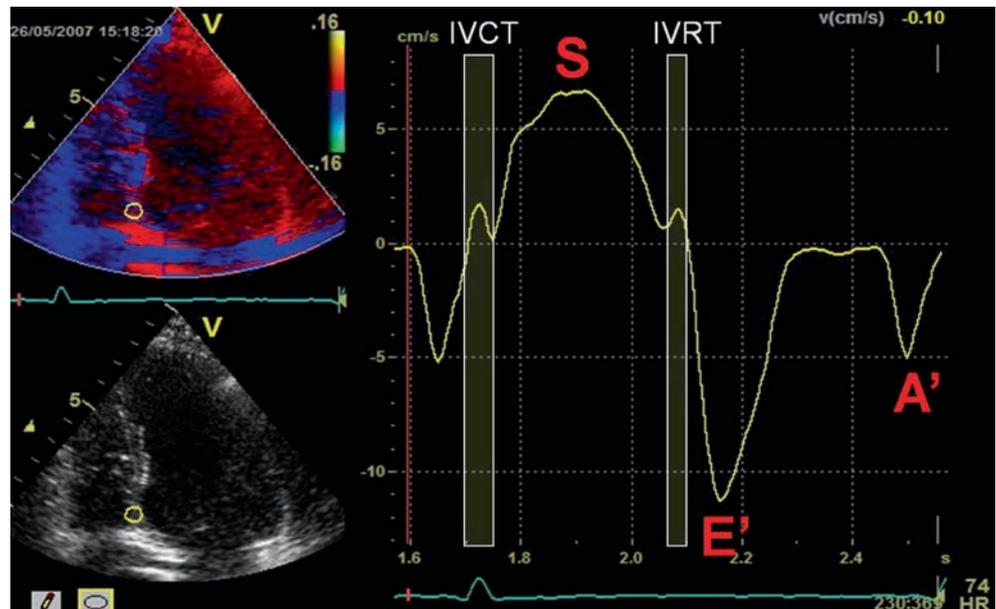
Example of a colour tissue Doppler velocity profile from the basal part of the interventricular septum of a young normal subject. *IVCT* isovolumic contraction time; *IVRT* isovolumic relaxation time; *S* peak systolic myocardial velocity; *E'* early diastolic myocardial velocity; *A'* regional myocardial motion due to atrial contraction
